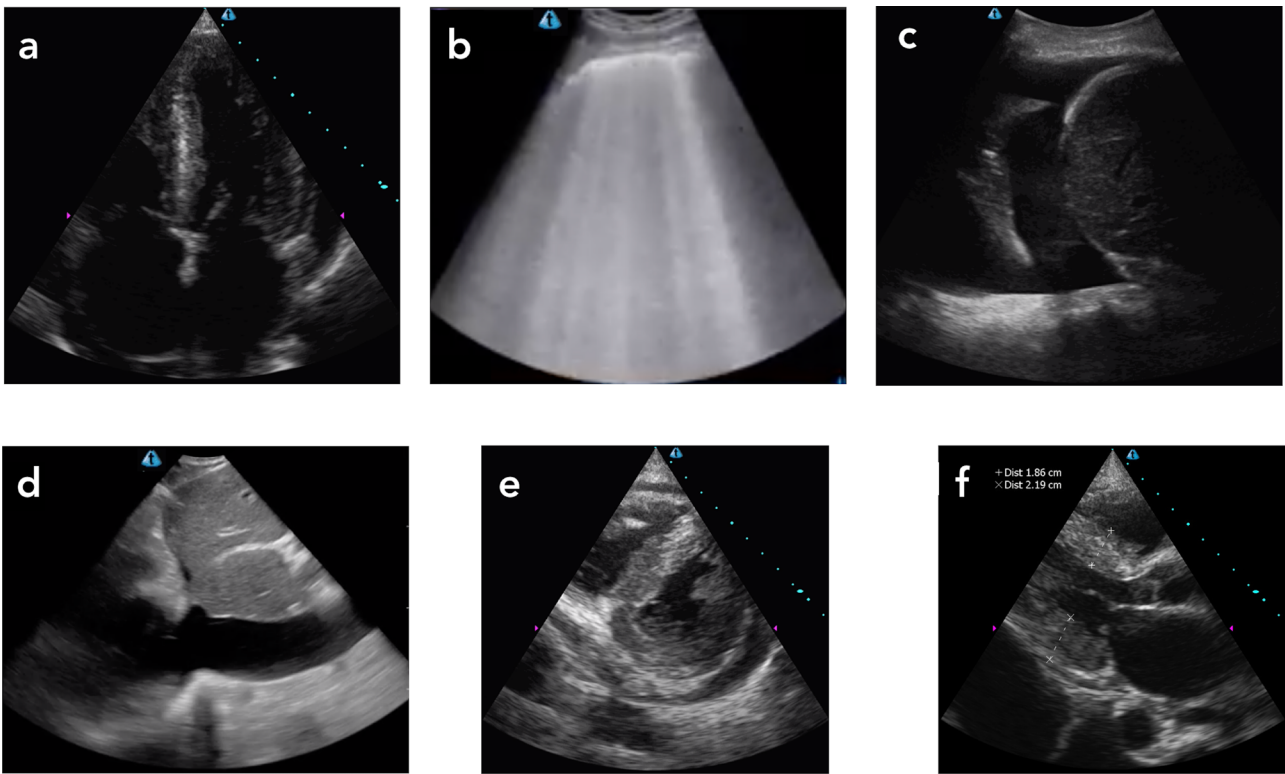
Ultrasound images obtained during the nephrological consultation: a. Heart with large atrial enlargements, increased thickness of the interventricular septum and pericardial effusion seen in the apical cardiac window; b. B lines seen in both lungs; c. Pleural effusion on the right, evidenced by the replacement of the mirror image of the liver by an anechoic image (liquid) and visualization of vertebral bodies above the diaphragm; d. "Plethoric" inferior vena cava without changing its diameter during the respiratory cycle. Cardiac image obtained through the paraesternal short axis window, showing interventricular septum paraesternal short axis window, with the left ventricle in a "D" shape due to the increased pressure and volume of the right ventricle, and pericardial effusion; f. Increased thickness of the interventricular septum and the left ventricular posterior wall in diastole and a large left atrium increase.
